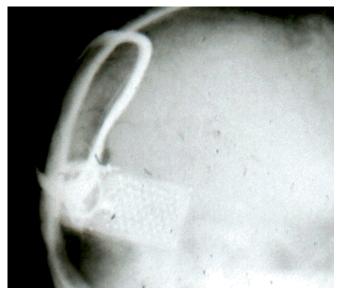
X-ray of electrode array on the mesial surface of the right occipital lobe.
